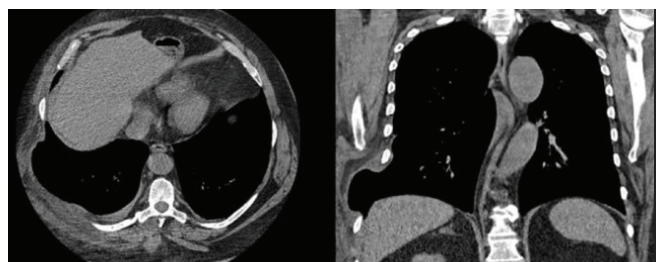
CT scan at the second presentation demonstrating minimal pleural effusion in the right hemithorax and a prominent lung herniation at the level of the right 8th intercostal space.
